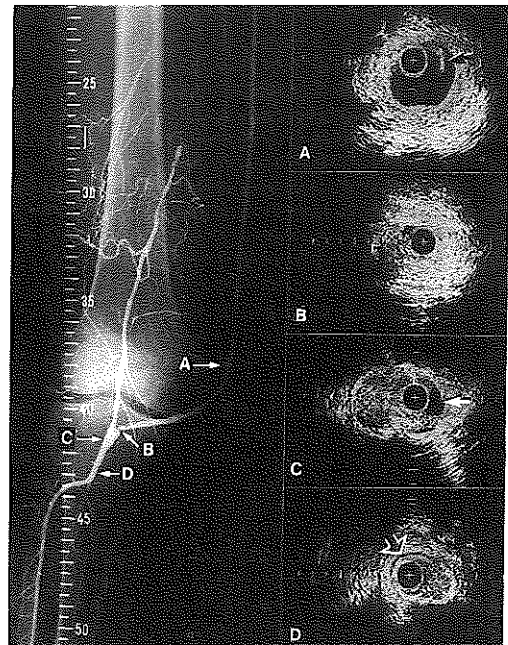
Angiogram with corresponding intravascular ultrasound cross-sections, revealing a patent anastomosis between the vein bypass graft and popliteal artery; proximal to the anastomosis a lesion is apparent (arrow). Intravascular ultrasound images (A–D) correspond to positions indicated on the angiogram. A, remnants of a vein valve (arrow) are seen echographically in the patent lumen. B, proximal to the anastomosis the diameter of the vein bypass graft is significantly reduced. C, the anastomosis is partly obstructed by a lesion (*). The black area (arrow) indicates saline flow unable to pass the anastomosis. D, distally a normal popliteal artery is seen. Open arrow: hypochoic media; calibration = 1 mm.
